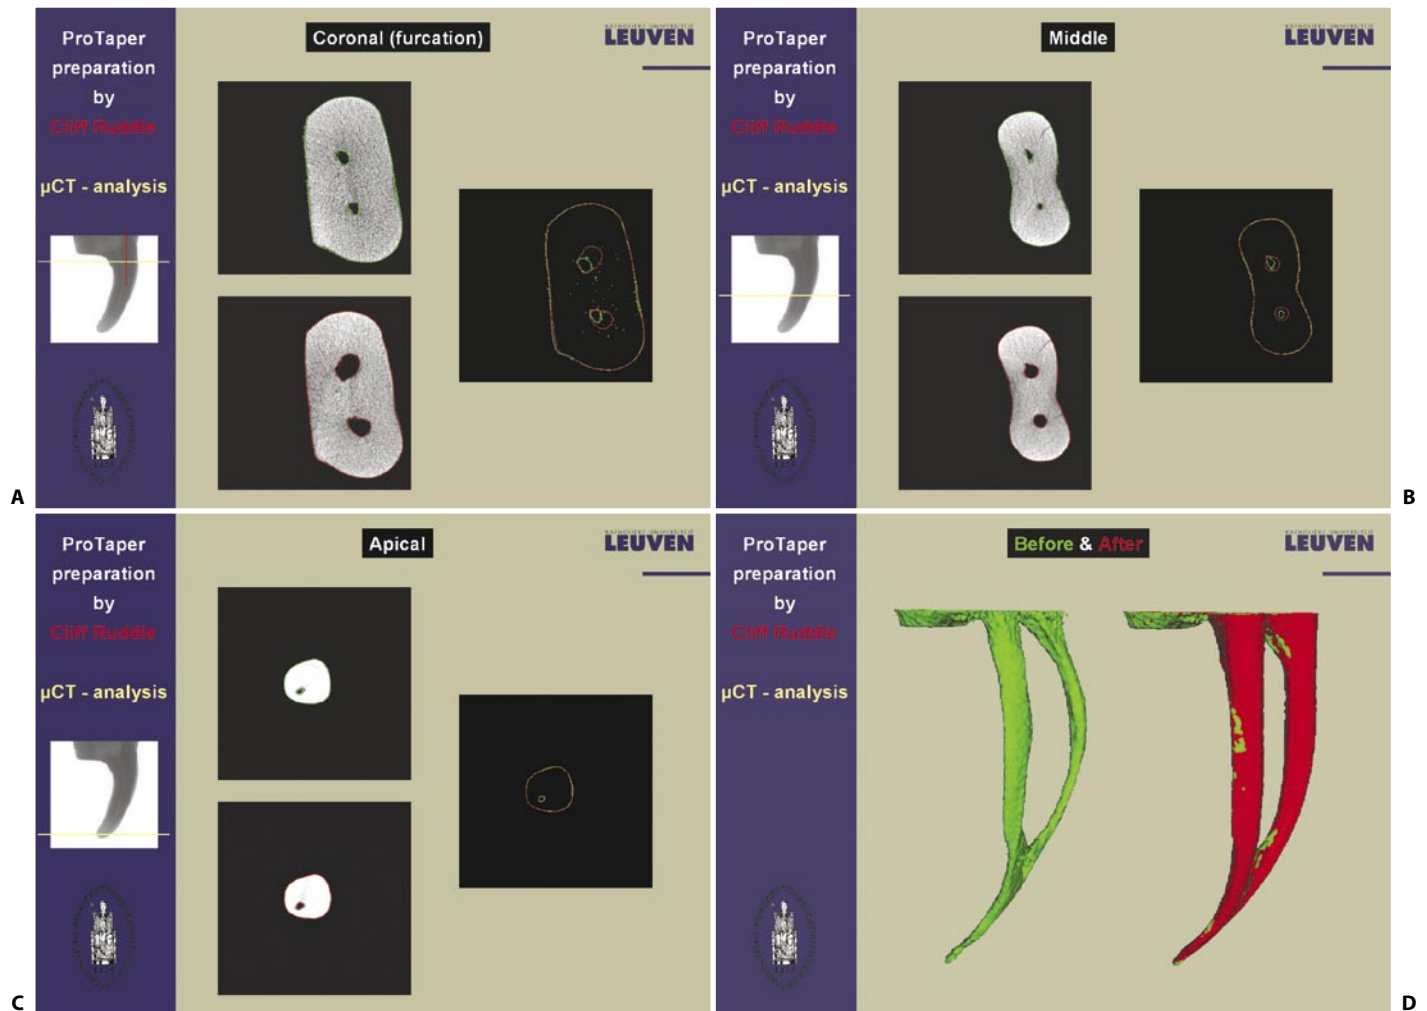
A. This figure shows horizontal μ CT sections through the coronal one-third of the root. Note the intentional and successful relocation of the canals at this level. B. This figure reveals horizontal μ CT sections through the middle one-third of the root. Note the ProTaper shapes are round and centered within the root. C. This figure shows horizontal μ CT sections through the apical one-third of the root. Note the ProTaper shape perfectly includes the original canal diameter. D. This figure compares before and after instrumentation with the S1, S2, and F1 files. Note the shapes are full, smooth flowing and centered, and the files have physically contacted virtually all the internal anatomy (Figs. 19.32 A-D, courtesy of Dr. Lars Bergmans and BIOMAT Research Cluster, Catholic University, Leuven, Belgium).
